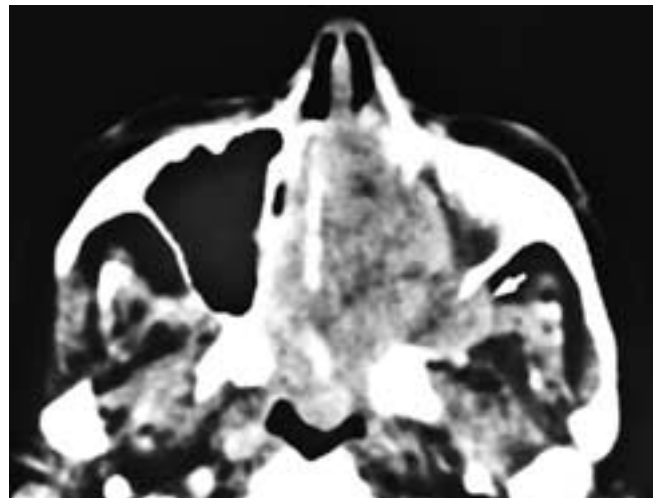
Axial contrast-enhanced CT scan shows a left nasopharyngeal and nasal fossa enhancing mass that has extended into the left antrum, widened the left pterygopalatine fossa, and extended into the left infratemporal fossa (*arrow*). There were only obstructed secretions in the right nasal fossa. This patient had an angiofibroma.
